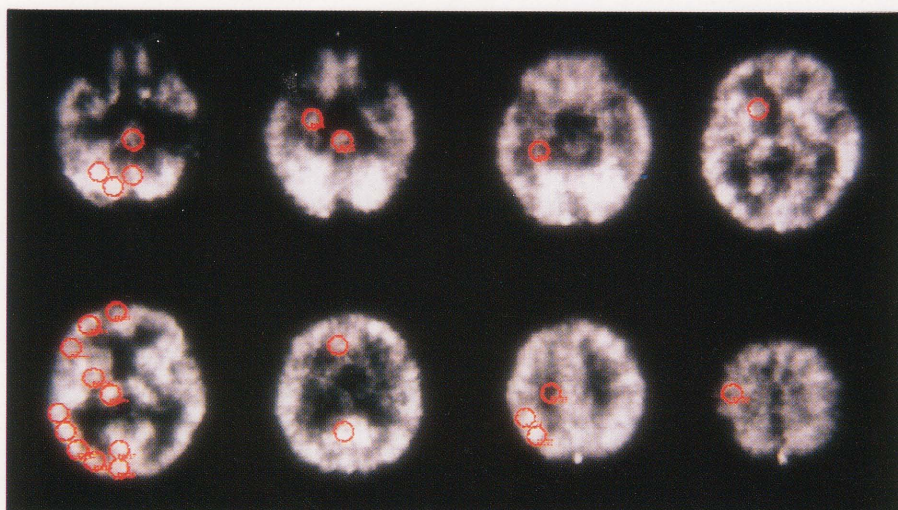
The CMRO₂ images with the regions of interest located on the major cortical gyri and the deep brain structure corresponding with the region of interests in MR images.
